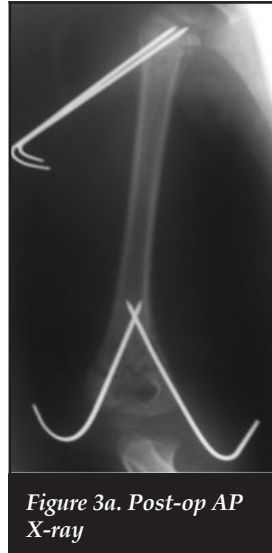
Post-op AP X-ray
